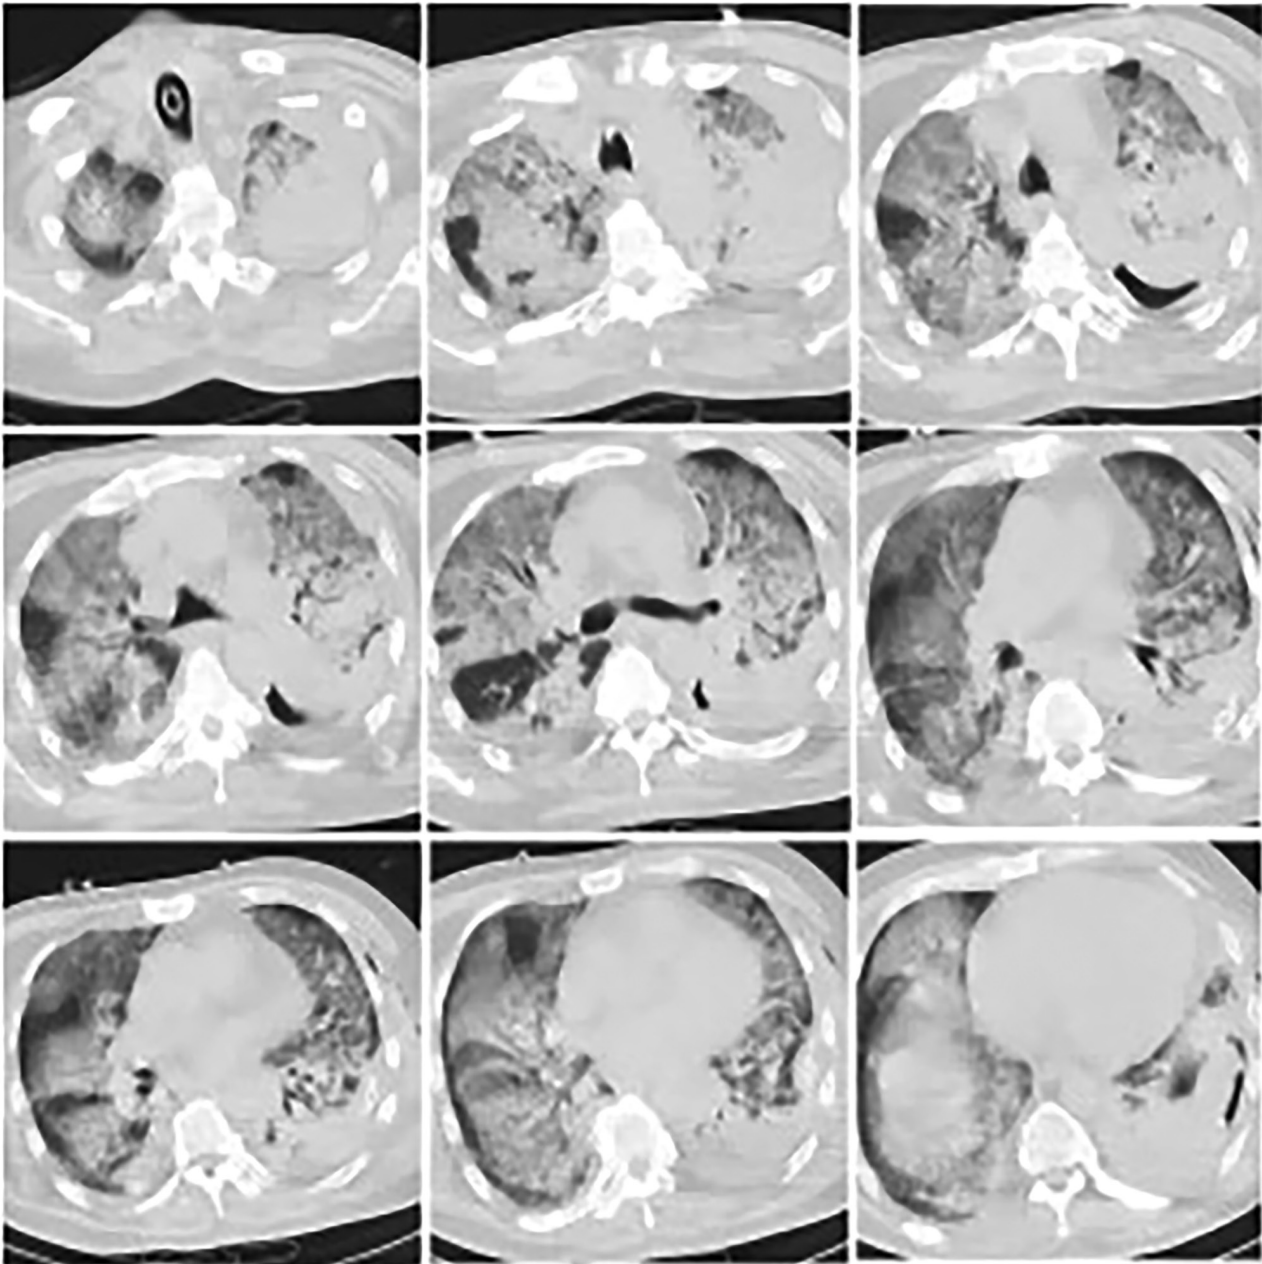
Chest computed tomography 32 h after admission showing multiple infections in both lungs and a large consolidation in the left lung.
